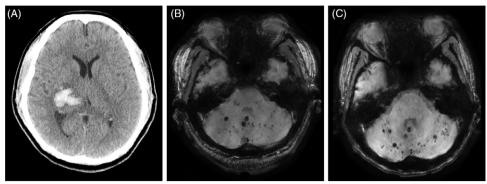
(A) Dry axial CT head showing intraparenchymal hemorrhage involving the right thalamus and posterior limb of the internal capsule. (B) Susceptibility weighted imaging MR brain without contrast performed on initial presentation showing diffuse multifocal cerebellar and pontine microhemorrhages. (C) Subsequent susceptibility weighted imaging MR brain without contrast performed 5 years after initial presentation showing progression of posterior fossa microhemorrhages.
